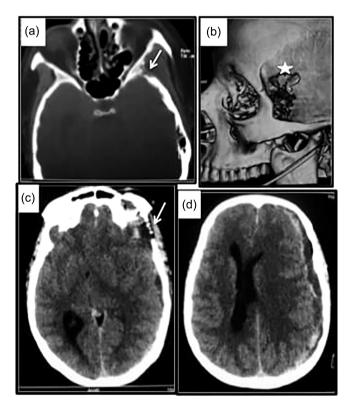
Preoperative images. (a) Axial cerebral CT Scan (bone slice) showing a "honey comb" appearance of the left spheno-temporal region (arrow); (b) CT Scan (3D image) showing the osteolysis with a large defect of the left spheno-temporal region (star); (c) Axial cerebral CT Scan showing an osteolysis of the temporal bone (arrow) and the beginning of the subdural left hematoma; (d) Axial CT Scan showing a left subdural hematoma with chronic and acute bleeding and a shiftiness of the midline.
